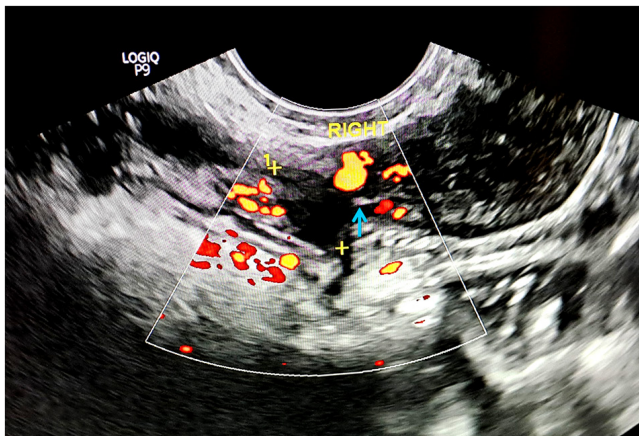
Color Doppler transvaginal ultrasonography demonstrating peripheral vascular flow surrounding the interstitial gestational sac. The interstitial line sign (blue arrow) is visible as an echogenic line extending from the endometrial cavity toward the gestational sac. The number '1' and the (+) symbols delineate the margins of the right interstitial mass.
